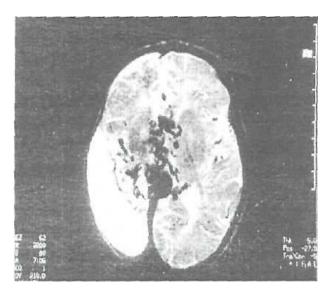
The cranial magnetic resonance imaging of the patient revealed an appearence fitting vein of Galen malformation and subdural effusion on the right
